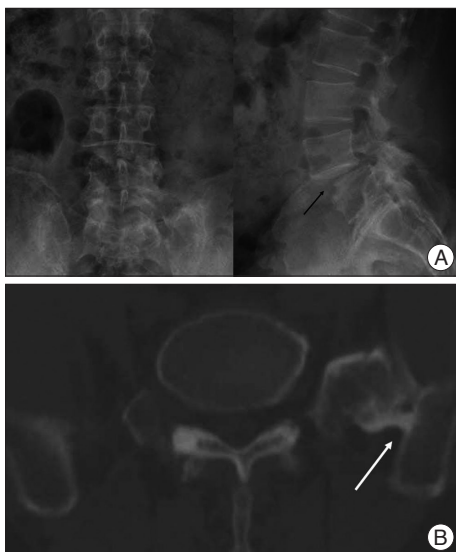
Preoperative plain radiographs (A) and CT (B) showing a L4-5 grade I isthmus spondylolisthesis, dysplastic L5 body (back arrow) and lumbosacral transitional vertebra which consists of a bony union between an L5 transverse process and the sacrum on the left side (white arrow).
